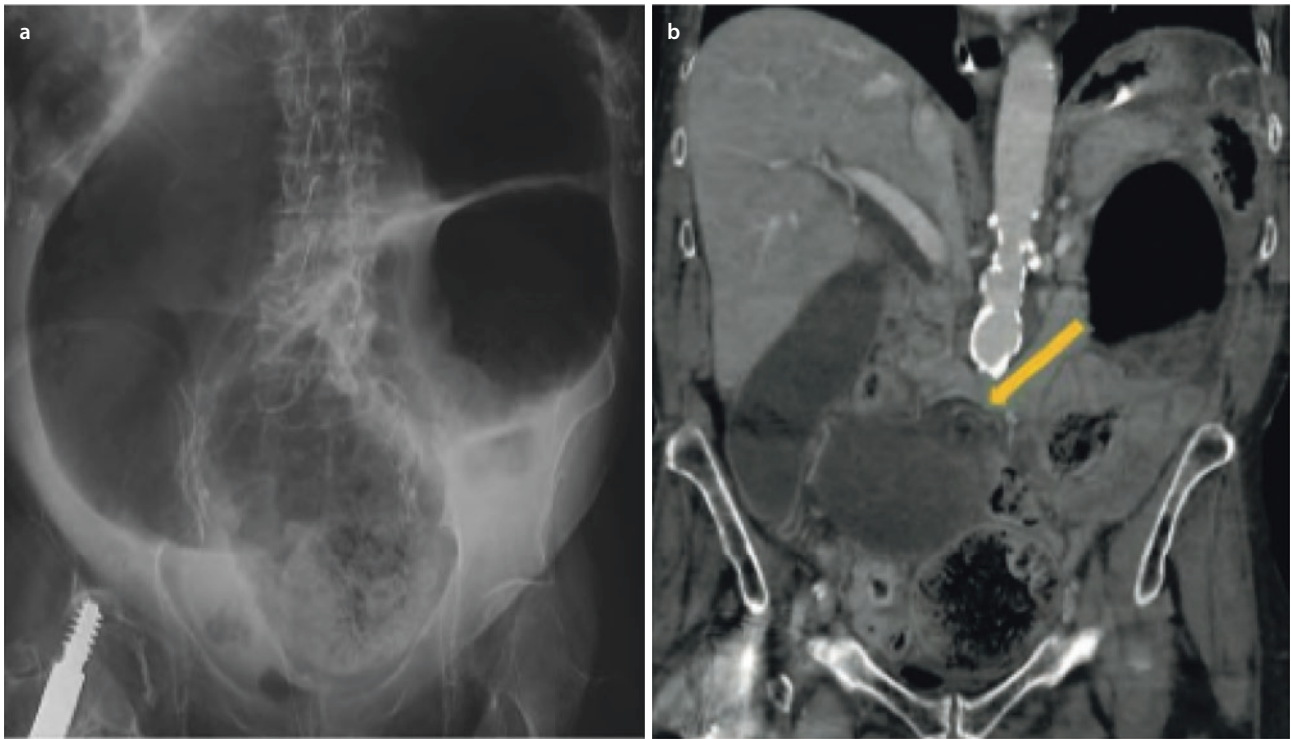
Volvulus of the sigmoid: a on flat plate, the sigmoid is highly distended in a typical “coffee bean” loop; b on CT scan, colonic distension is clearly visible and a “swirl” of the mesenteric vessels twisted by the sigmoid rolling is detected (indicated by the arrow). (Photos from R. Déry)
